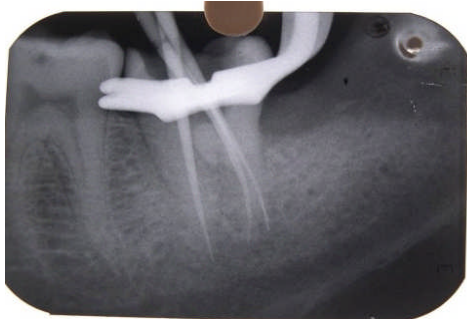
Check X-rays with master cones in the canals
